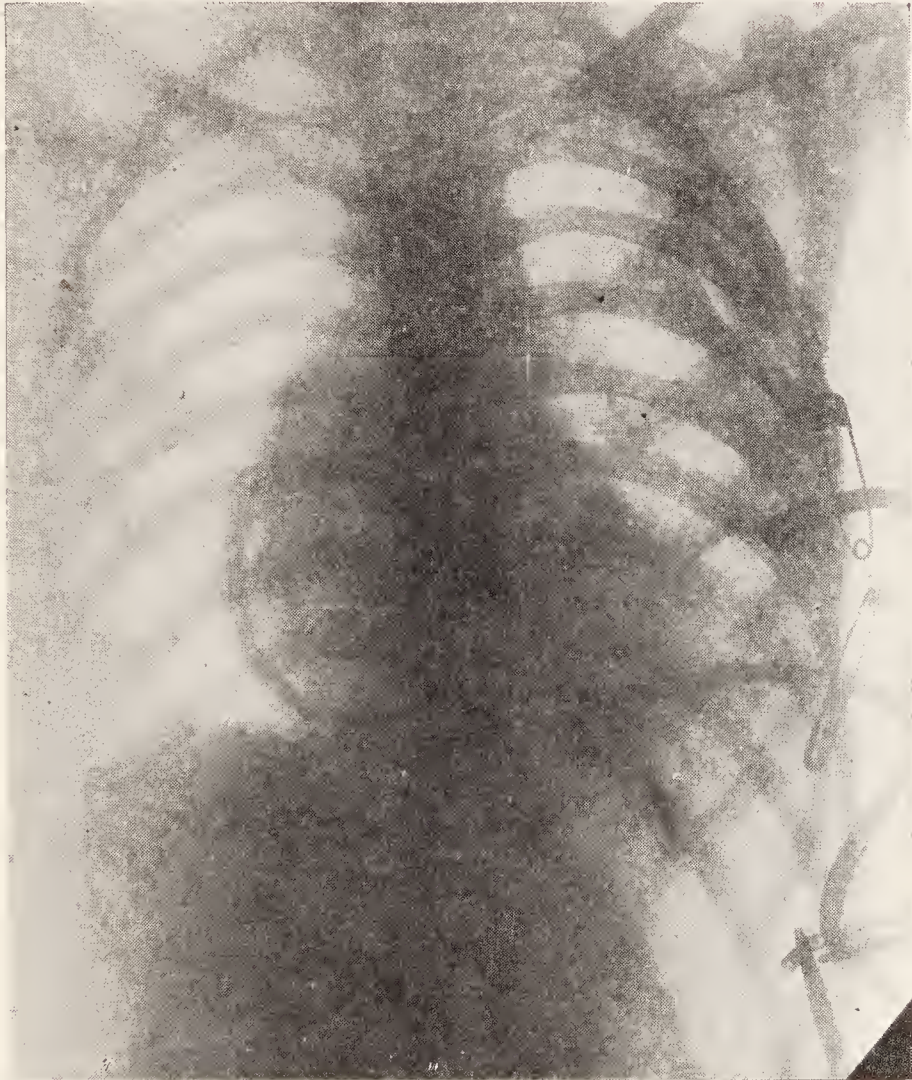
Catheter coming from left, going under base of heart, and draining posterior sulcus of pericardium. Dr. Wyman Whittemore. (Roentgenological Department, Massachusetts General Hospital.)
